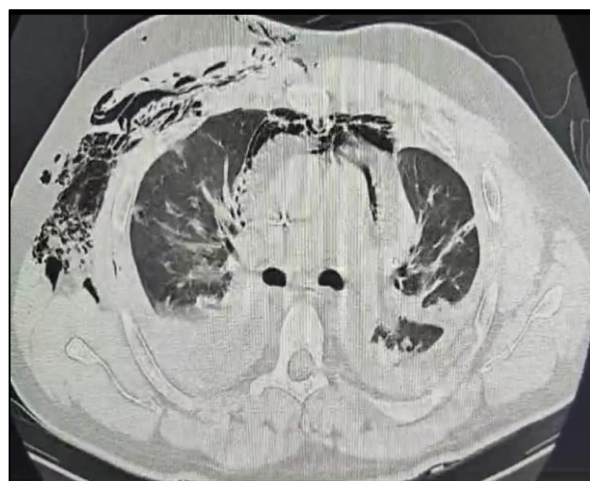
CT scan of the Chest - bilateral lung contusions, hemo-pneumothorax left side, and pneumomediastinum, with chest-tube in the right pleural cavity.
